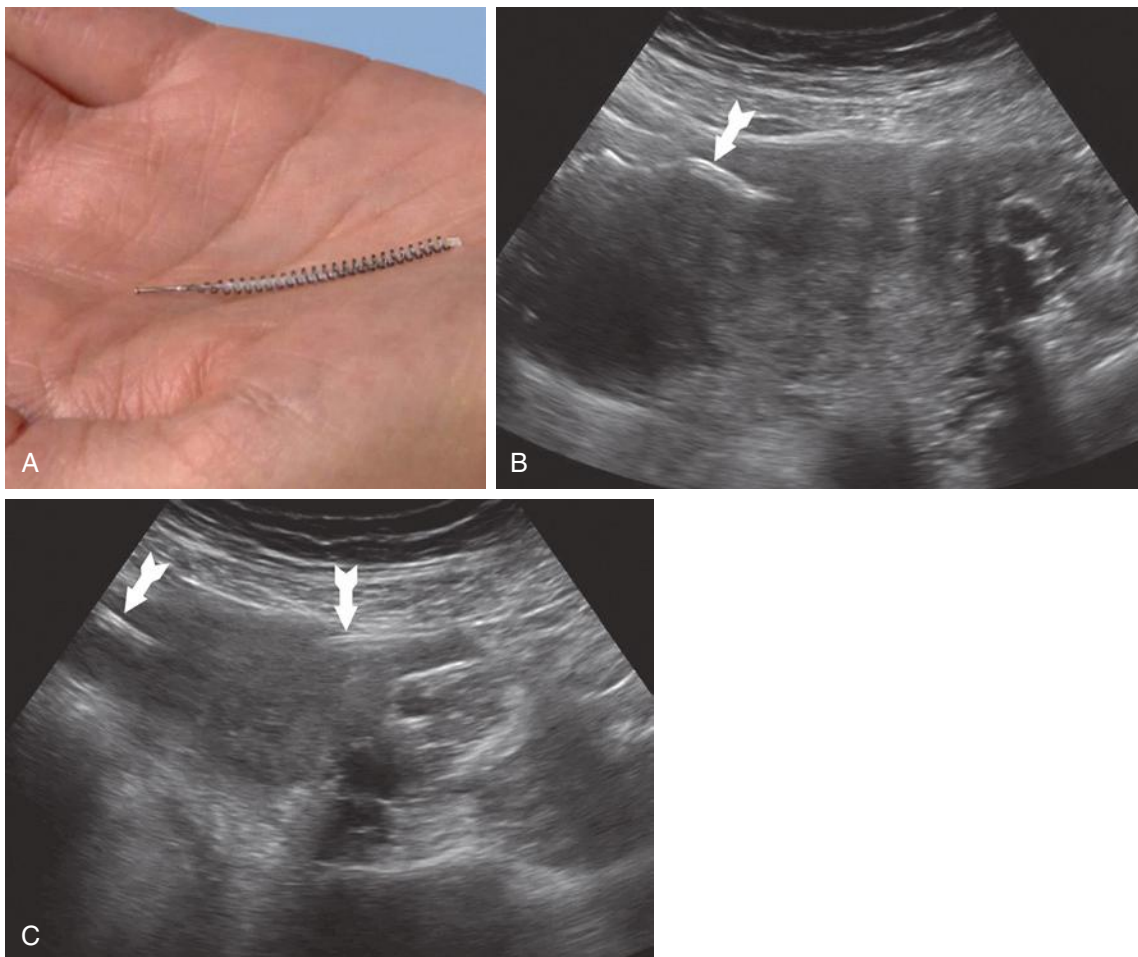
Essure microinserts. A, Photographic image from the manufacturer's website (device is placed in a human hand to show scale). B, Transabdominal, transverse sonographic image of the uterus showing the right-sided linear echogenic insert (*arrow*) in the interstitial portion of the fallopian tube, traversing the myometrium. C, Additional transabdominal transverse view of the uterus showing both right and left echogenic linear inserts (*arrows*). (A from Bayer HealthCare Pharmaceuticals: What is Essure? September 2015. Available at www.essure.com.)
